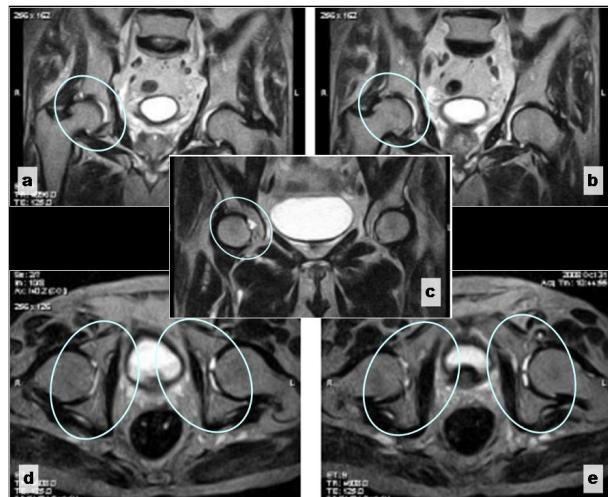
MRI T2 sequence: (a-c): Core; (d-e): Axial.
